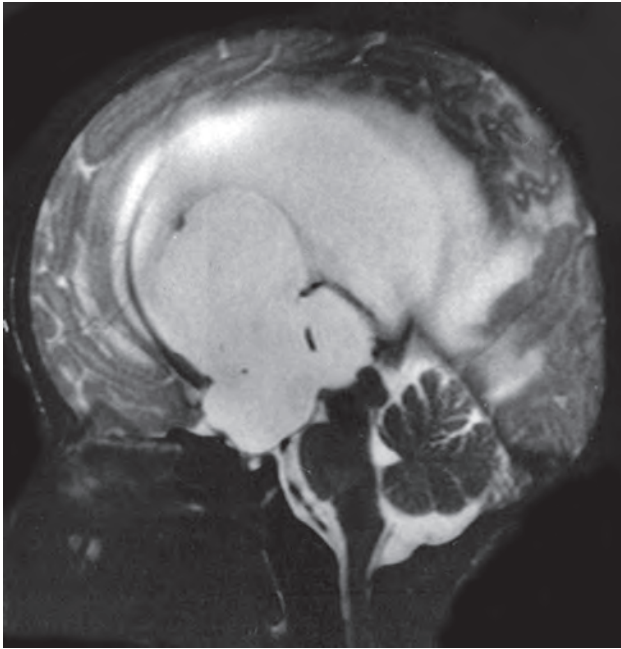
Sagittal T2-weighted MRI scan of a child with obstructive hydrocephalus showing a long segment aqueductal stenosis. Note the bifurcation of the basilar artery which is placed anteriorly considerably diminishing the space for an endoscopic third ventriculostomy to be performed
